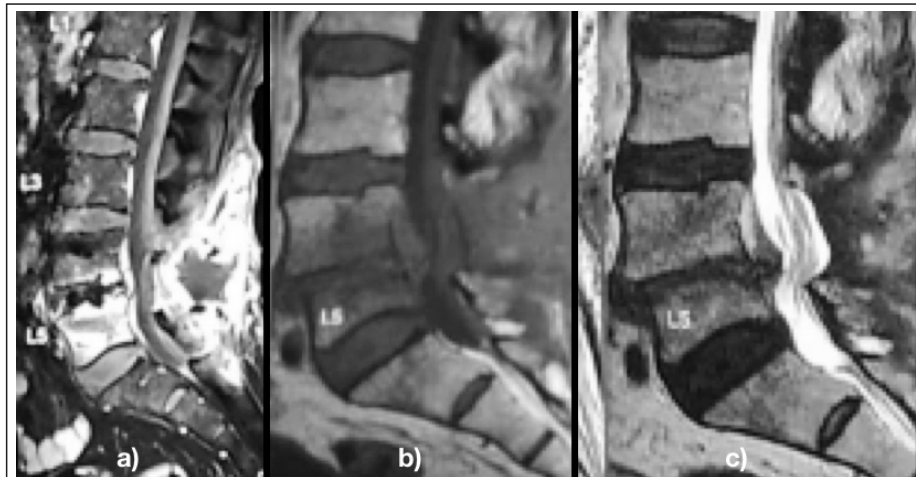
Sequential MRIs a) MRI 4 months from index surgery after repeated debridements now shows disc space infection with loosening of cage and vertebral body involvement b) MRI after removal of implant and cage
